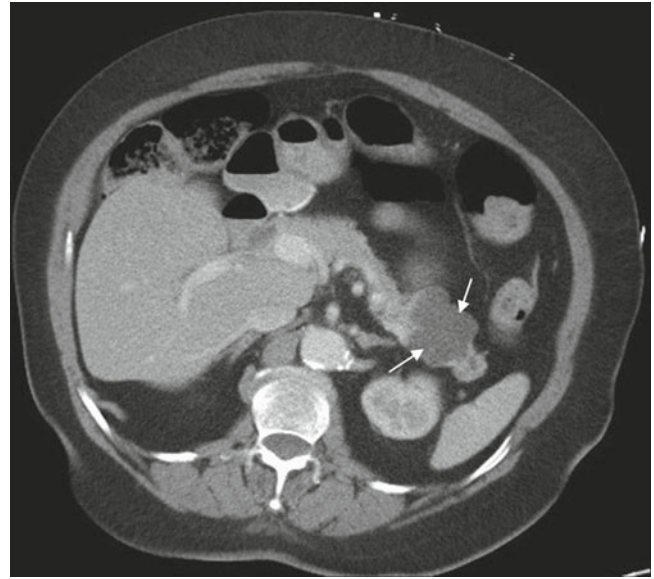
A 76-year-old asymptomatic man had a chest CT as part evaluation to exclude lung cancer because of a long history of smoking. On a prior image of that CT a pancreatic mass was suspected, so a dedicated CT abdomen and pelvis was done. Axial intravenous contrast enhanced CT image at the level of the body and tail of the pancreas shows a 3.5 cm multilobulated mass (*white arrows*) with low attenuation material (40 HU—soft tissue density, not fluid) with enhancing borders, suggesting a cystic tumor. Diagnosis: Cystic tumor, tail of pancreas
